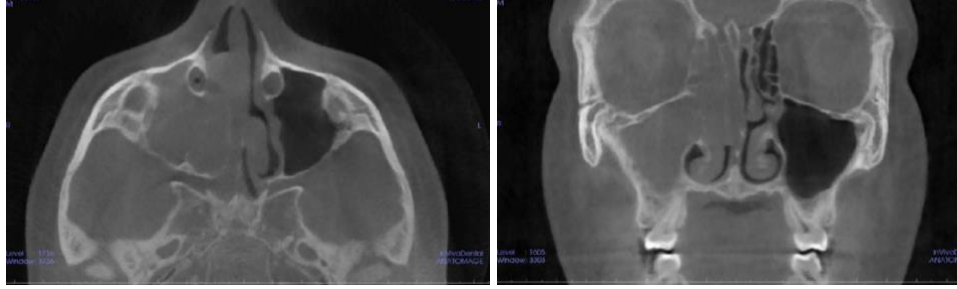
Axial (left) and coronal (right) CBCT cross-sections depicting complete opacification of the right paranasal sinuses, suggestive of sinusitis. Referral to an otolaryngologist is suggested for further evaluation.
